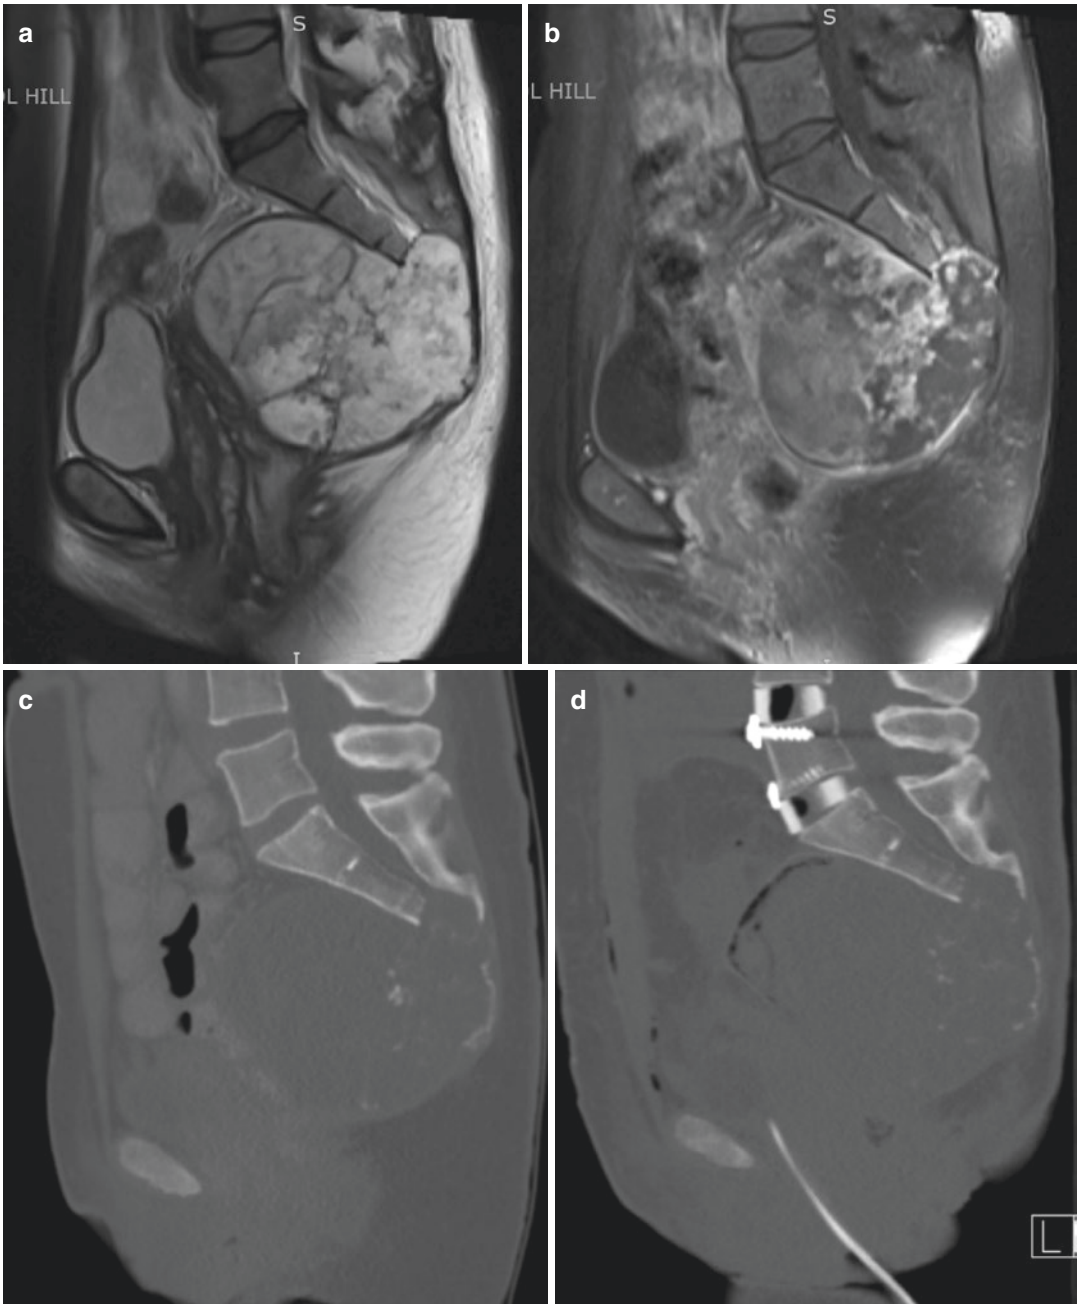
In a 50-year-old patient with a large sacral chondrosarcoma, we elected to use navigation in an effort to maximize preservation of bone at S1. Sagittal (a) T2 MRI, (b) postcontrast MRI, and (c) CT demonstrating a large sacral mass without involvement of S1. Stage 1 involved anterior exposure with ALIFs at L4/5 and L5/1. Poststage 1 CT allows visualization of interbody grafts as well as up-to-date imaging of tumor (d). Given efforts to
